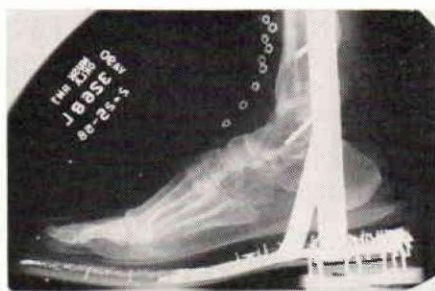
X-ray of Foot in Special Shoe with Sole Plate and Brace. Note Fused Ankle Joint.
